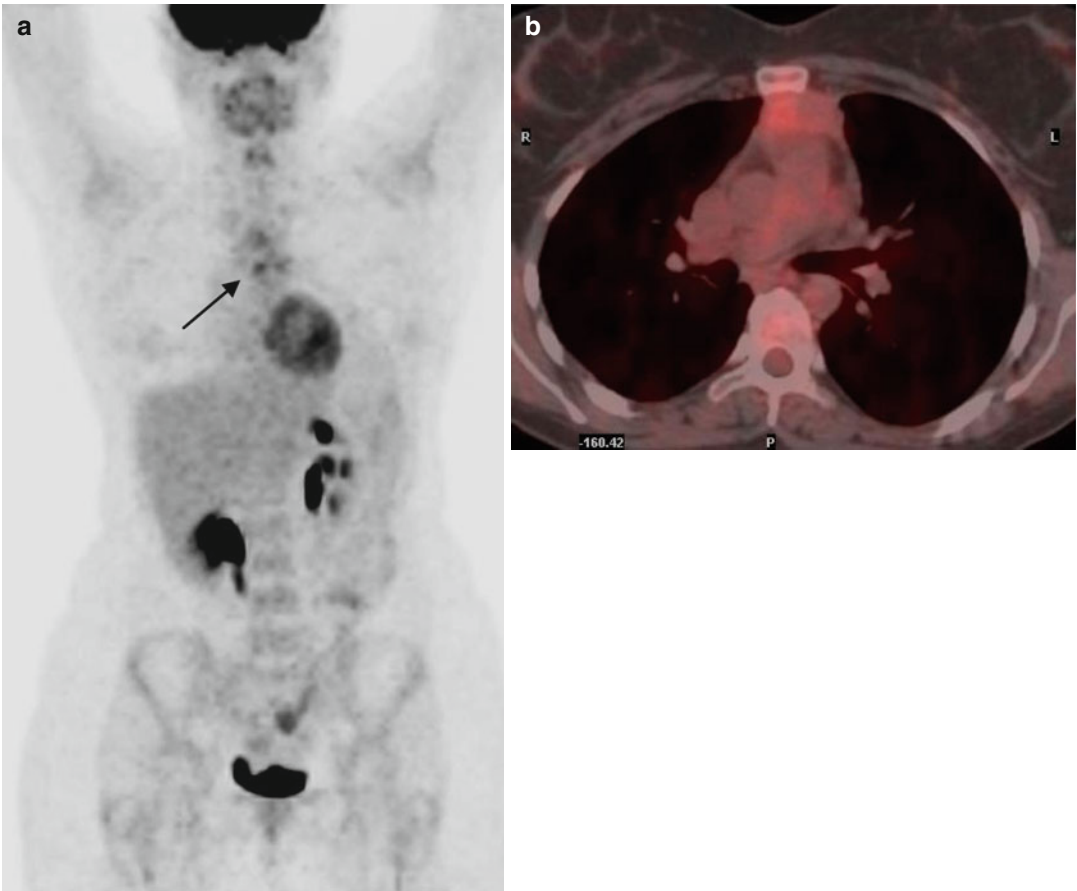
(a, b) MIP-PET and fused PET/CT post immunochemotherapy with R-CHOP: Residual hypermetabolic mediastinal mass (*arrow* in the MIP image) with uptake exceeding that of the liver (D5-PS score 4)
